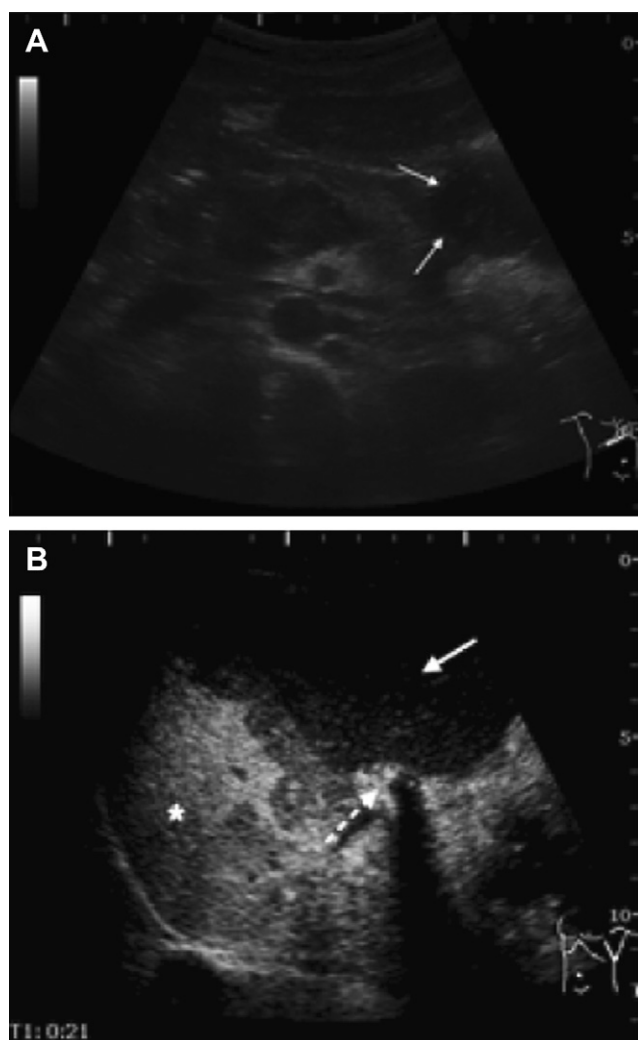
(A) Postsurgical ultrasound examination (transverse section) revealed an inhomogeneous pancreatic area and the presence of a hematoma (arrows). (B) Postoperative contrast-enhanced ultrasound examination of the spleen (longitudinal section) showed normal spleen parenchyma (asterisk), splenic artery with contrast agent (pointed arrow), and infarction area (arrow).
